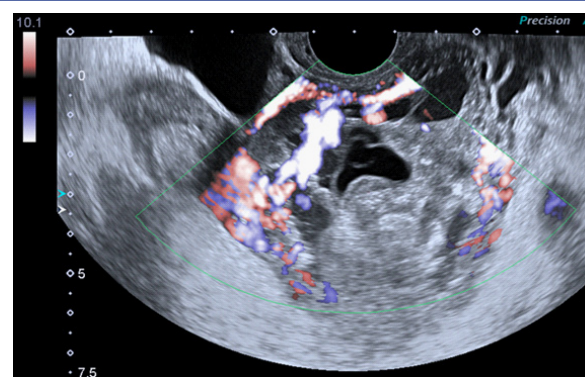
TVS in Case No. 1 showing marked hypervascularity of the trophoblastic mass on colour Doppler study. The empty uterus above was missed.
